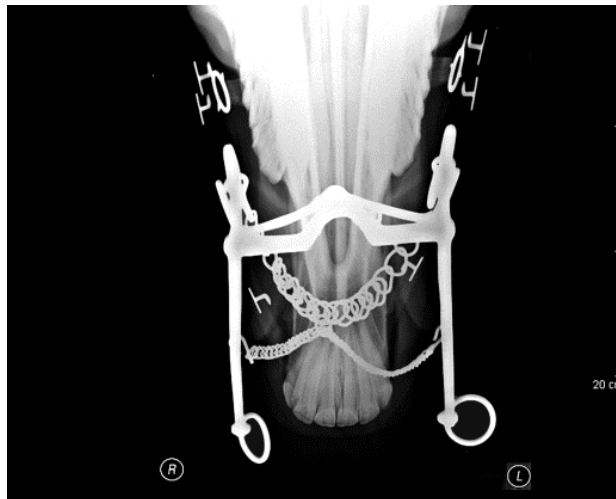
Dorso-ventral radiograph of the equipment mandated by the FEI and national federations for the upper levels of dressage
